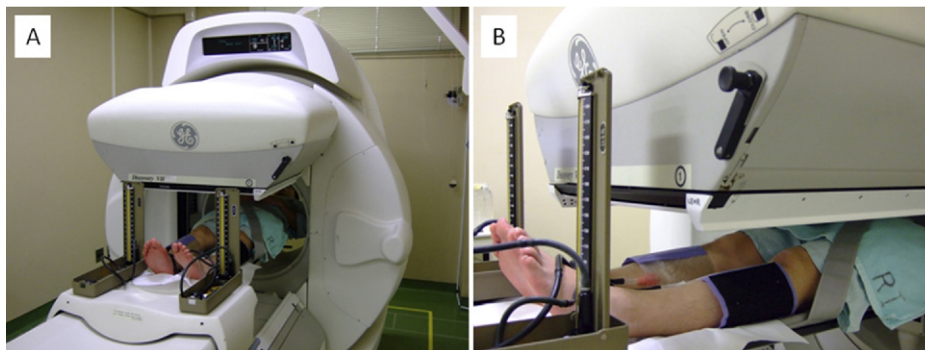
Measuring lymphatic pumping with lymphoscintigraphy. Lymphatic pumping was measured with the individual supine under the gamma camera. Sphygmomanometer cuffs were wrapped around the bilateral lower legs.
